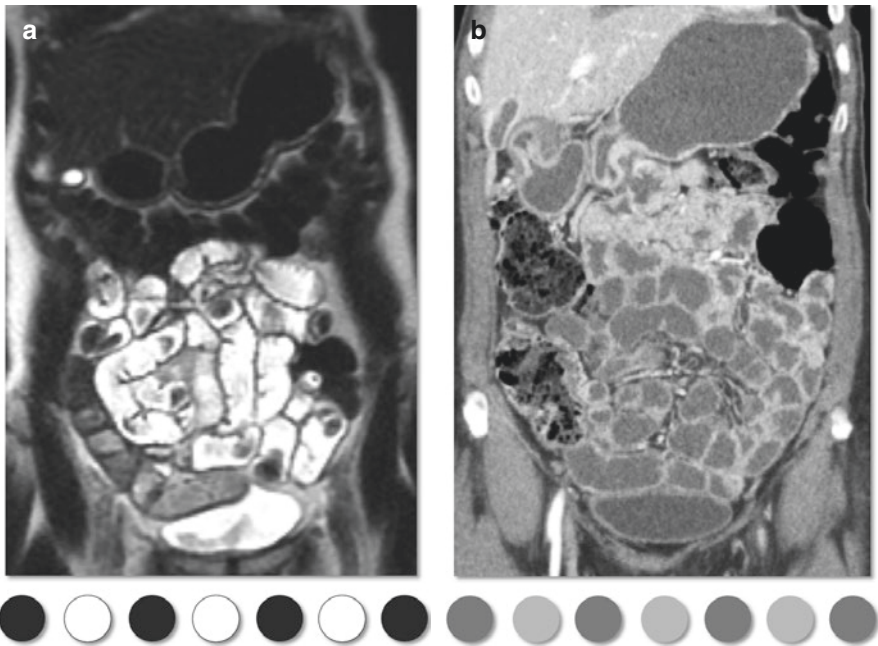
Coronal heavily T2-weighted image (a) and coronal CT enterography image (b). With MRI, the difference in signal intensity between the fluid in the lumen and bowel wall is greater than the density difference on CT which can increase the conspicuity of bowel abnormalities compared to CT
